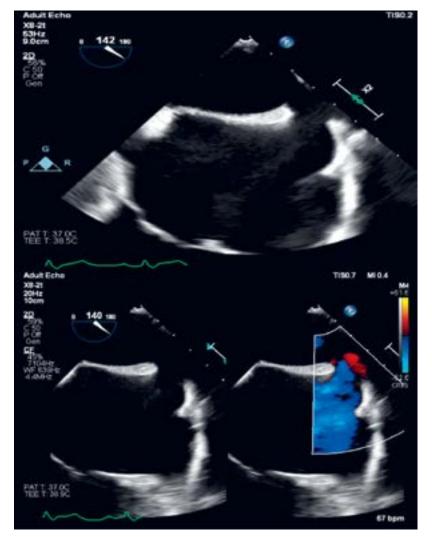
Transoesophageal echocardiography showing sinus venosus atrial septal defect.
